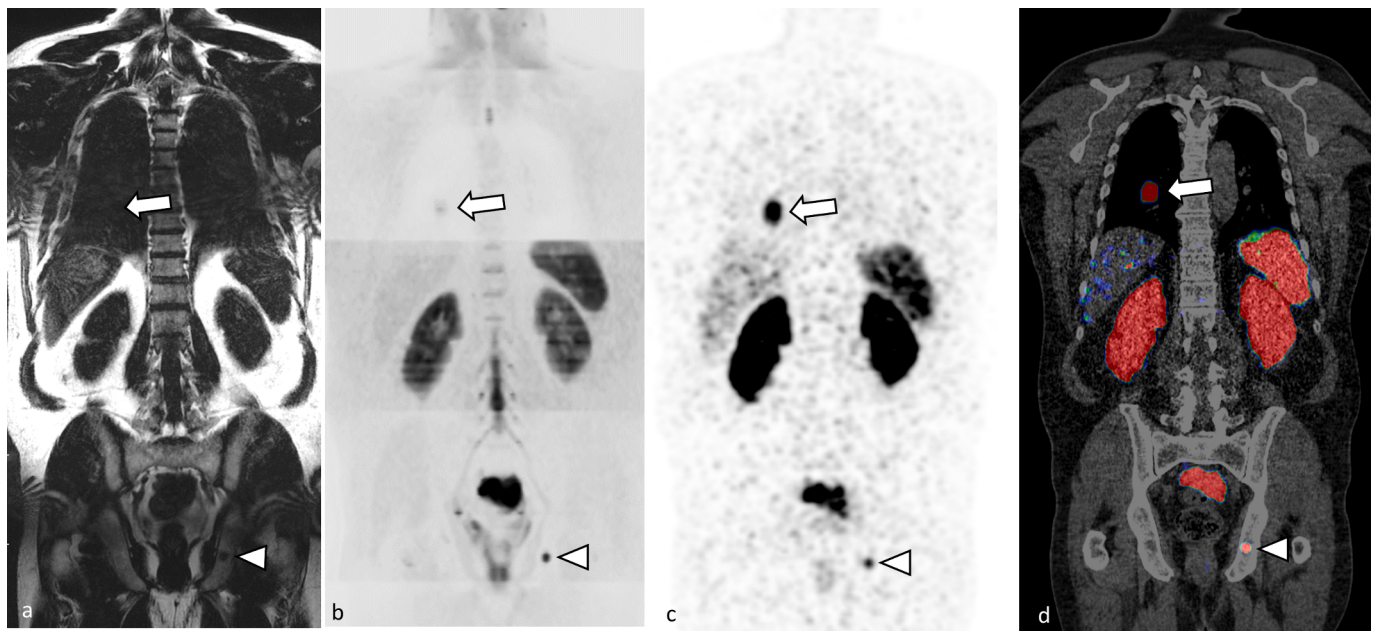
Concordant evaluation of distant extension between fast “All-in-One” WB-MRI and ^{68}Ga -PSMA-PET/CT in a 63-year-old man with high-risk PCa. Panels a-b (fast “All-in-One” WB-MRI) show coronal WB-MRI T1 Dixon Fat only (a), and coronal reformatted DWIBS ($b = 1000 \text{ s/mm}^2$; inverted grey scale) images showed right lung (arrow) and left ischiopubic bone (arrowhead) metastasis (arrow) (b). Panels c-d (^{68}Ga -PSMA-PET/CT) show coronal metabolic PET (c), and coronal reformatted fused PET/CT with the same lung (arrow) and bone metastasis with PSMA expression (arrowhead) (d).
